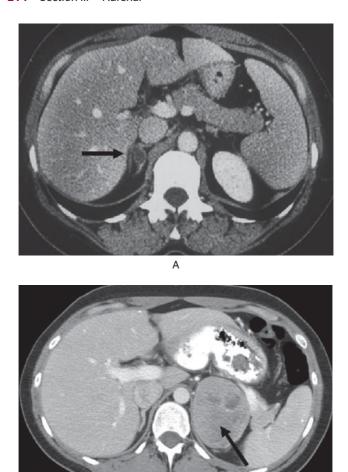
A. Axial computed tomography (CT) image showing a small adrenal cortical adenoma (*arrow*). B. Axial CT image showing a large left adrenocortical carcinoma (*arrow*). C. Axial CT image from a patient with adrenocorticotropic hormone–independent macronodular adrenal hyperplasia showing massively enlarged adrenal glands (*arrows*) bilaterally.
